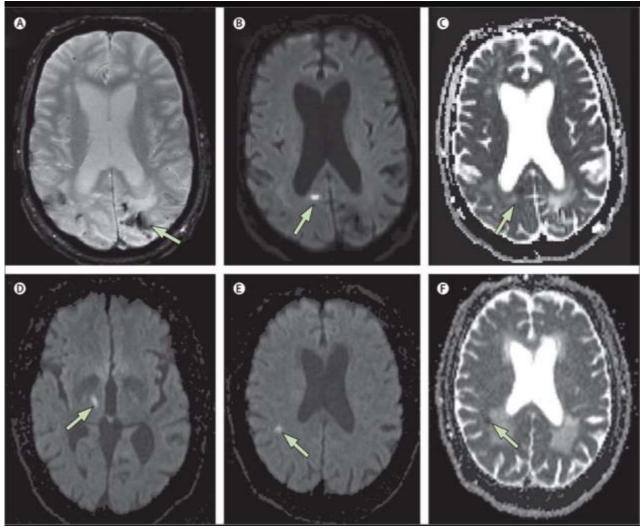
MRI acute infarction
